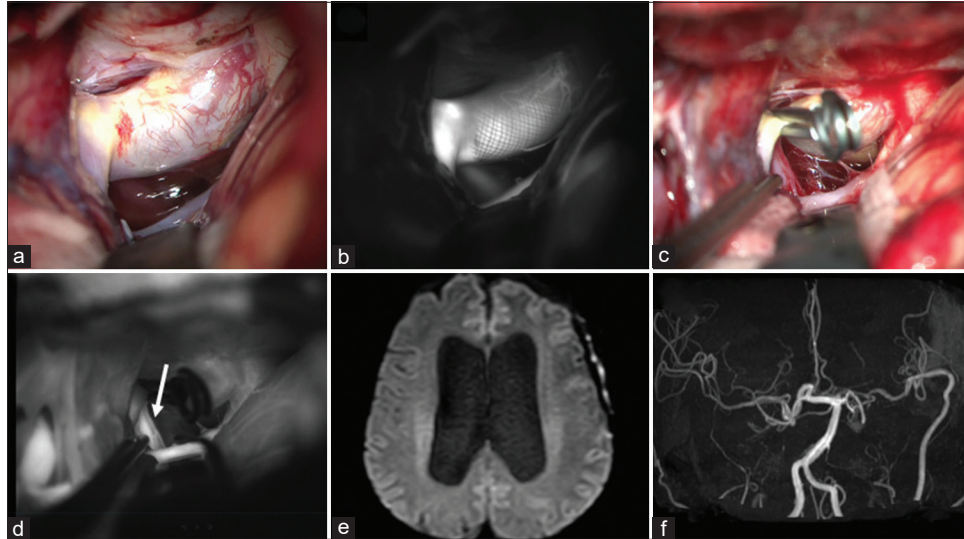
The flow diverter stent was identified (a) and indocyanine green (ICG) angiography showed the distal edge of the stent clearly (b). The internal carotid artery was trapped (c) and ICG angiography demonstrated retrograde flow of the posterior communicating artery was observed (d, arrow). Postoperative magnetic resonance imaging (e) and angiography (f) showing no ischemia and bypass patency.
